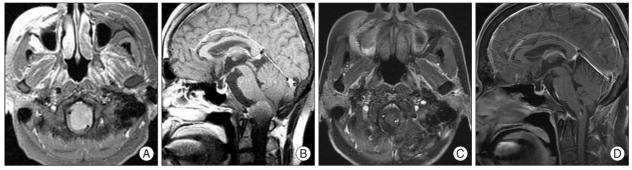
Pre- and postoperative radiological findings in ventral type foramen magnum meningioma. Preoperative MRI showed a 2.5 × 2 cm sized extra-axial enhancing mass in cervicomedullary junction with displacement of adjacent brainstem (A and B). There was no recurrence during 4 years after surgery (C and D).
